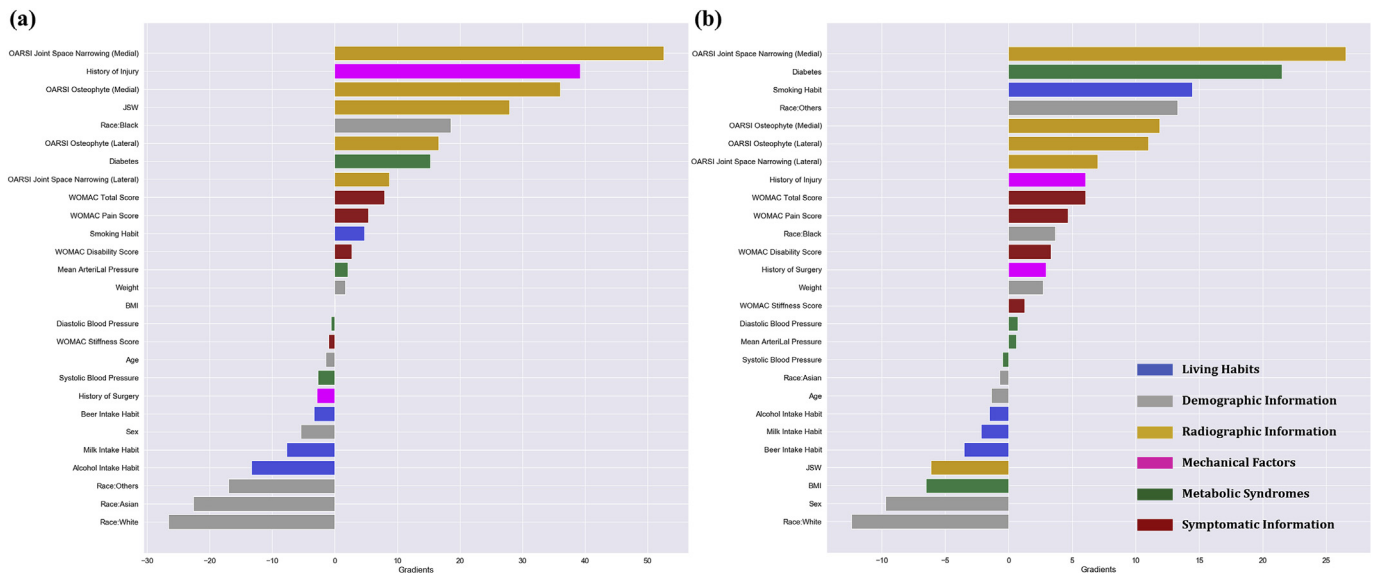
DeepLIFT gradient plots of the input risk factors. The risk factor categories are indicated by different colors, blue for living habits, grey for demographic information of the subjects, orange for radiographic information, pink for mechanical factors, green for metabolic syndromes and brown for symptomatic information. (a) Demonstrates the gradient of each risk factor in the KOA onset prediction and (b) displays gradients in the prediction of KOA deterioration. Positive gradient would indicate that as the value of the feature increases, the prediction of positive class (i.e. progressors) is favored. Contrariwise, a negative gradient implies increasing the feature value would result in a higher tendency of prediction towards the negative class (i.e. non-progressors). Meanwhile, the magnitude of the gradient correlates to the extent of influence and contribution in the model’s prediction.
